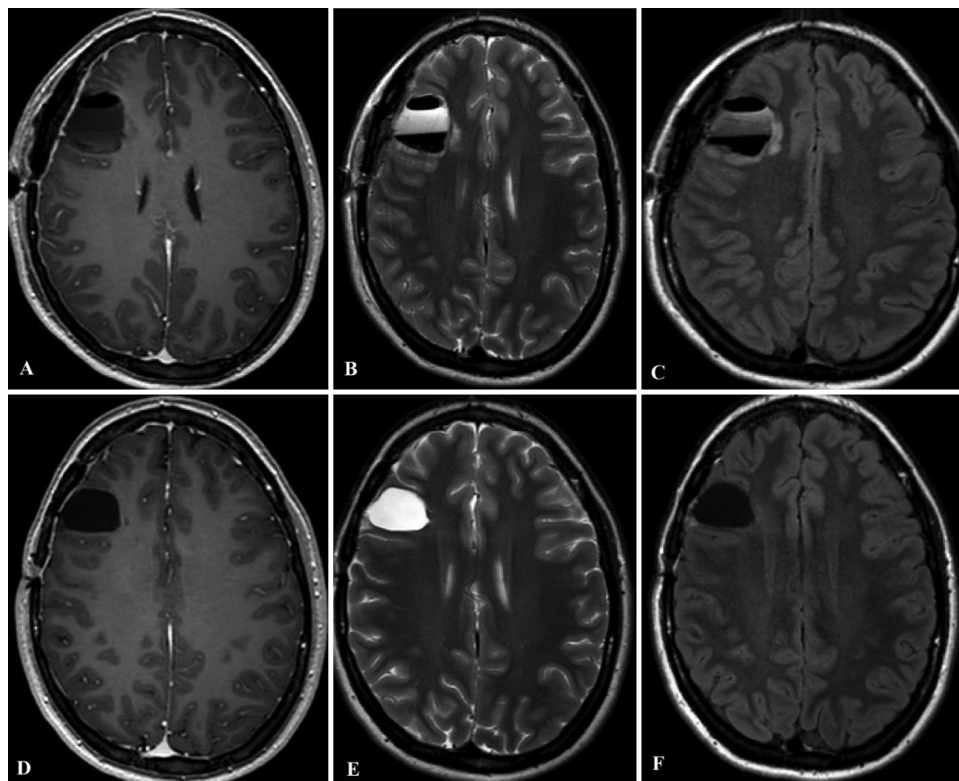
Postoperative axial contrast-enhanced T1-weighted (A and D), T2-weighted (B and E), and FLAIR (C and F) images after the redo resection. A–C: Initial scans obtained on postoperative day 2, demonstrating a fluid-filled right frontal resection cavity with minimal diffusion restriction and T2-FLAIR hyperintensity along the rim of the resection cavity. D–F: Delayed scans obtained 6 months postoperatively, demonstrating reduction in the size of the surgical cavity with reduction in the surrounding signal abnormality and no new signal abnormality or abnormal enhancement at the surgical site.
